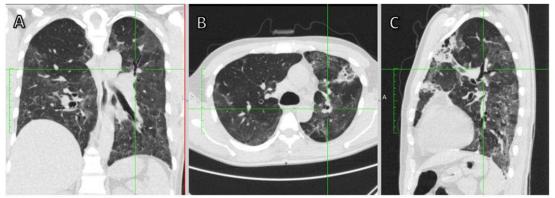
Coronal, axial, and sagittal section, lung window, chest CT scan of 45 years old male, after COVID-19 patient, showed fibrosis, bronchiectasis and GGO.
